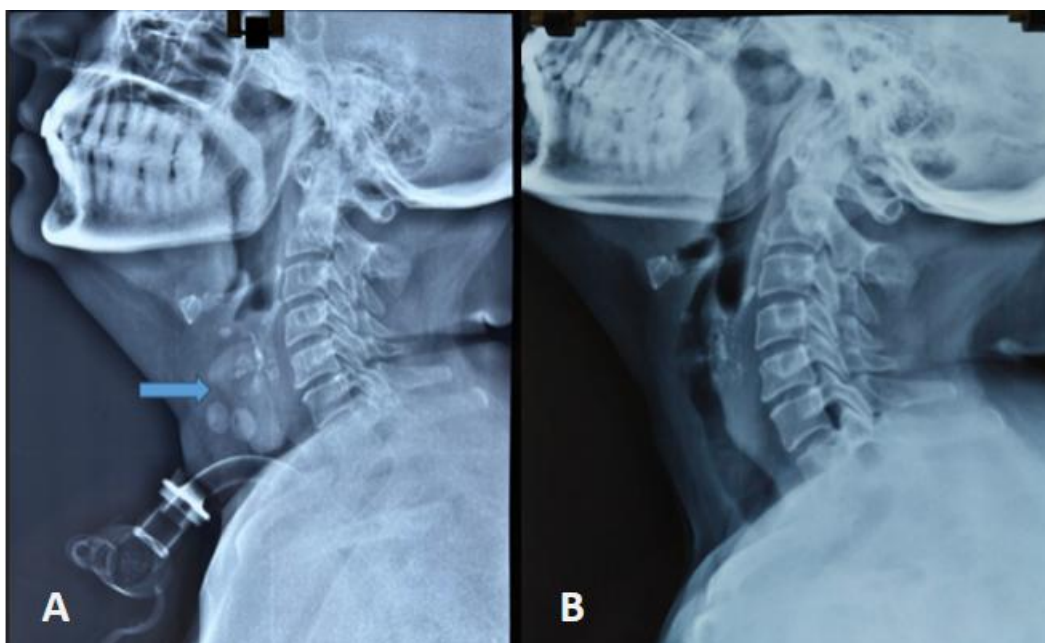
post-operative x-ray neck lateral view showing the laryngeal stent insitu
